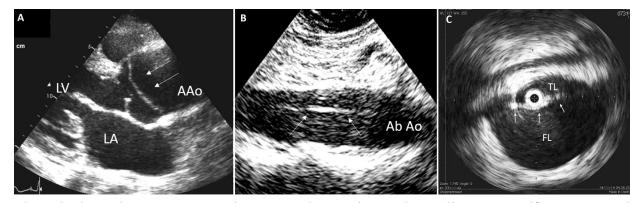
Cardiovascular ultrasound imaging in acute aortic dissection. (A and B) Aortic dissection diagnosed by TTE: (A) Intimal flap (arrows) is visualized in the aortic root; (B) intimal flap (arrows) in abdominal aorta. (C) Descending aorta dissection showed by intravascular ultrasound (IVUS). The intimal flap (arrows) is visualized between FL and true lumen TL. Abbreviations: AAO, ascending aorta; Ab Ao, Abdominal aorta; FL, false lumen; LA, left atrium; LV, left ventricle; TEE, transesophageal echocardiography; TL, true lumen; TTE, transthoracic echocardiography.
